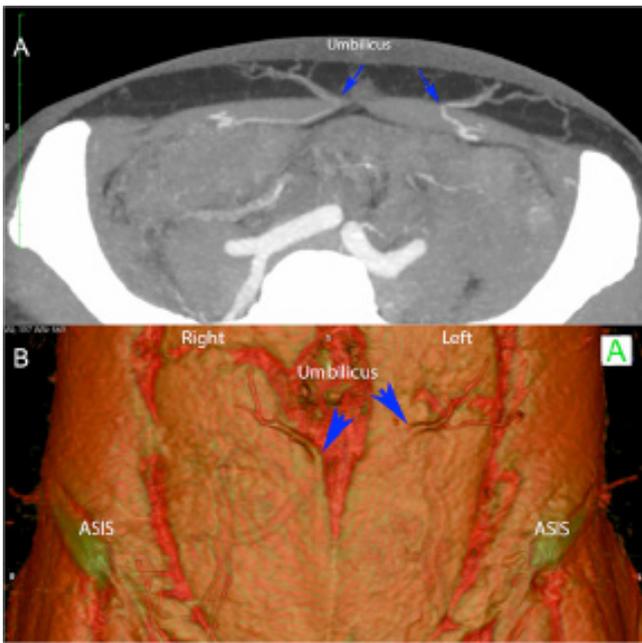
Computed tomographic angiography (CTA)-based three-dimensional (3D) perforator mapping in deep inferior epigastric artery perforator (DIEP) flap planning performed using OsiriX software. (A) Maximum intensity projection (MIP) reconstruction demonstrating the intramuscular and subcutaneous course of each perforator, and (B) Volume-rendered technique (VRT) reconstruction demonstrating the location of the perforators (blue arrows) as they emerge from the rectus sheath in reference to the umbilicus (marked)
